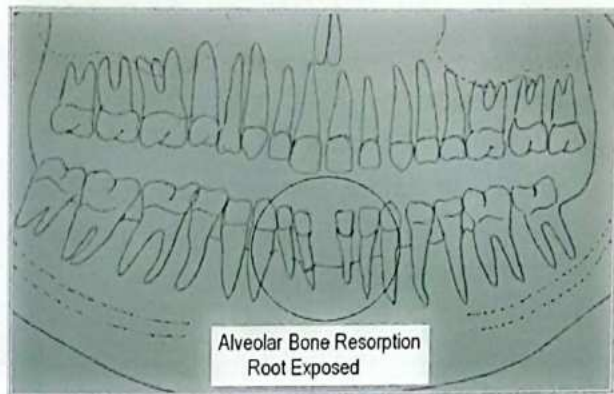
Pretreatment Panoramic Radiograph and tracing
